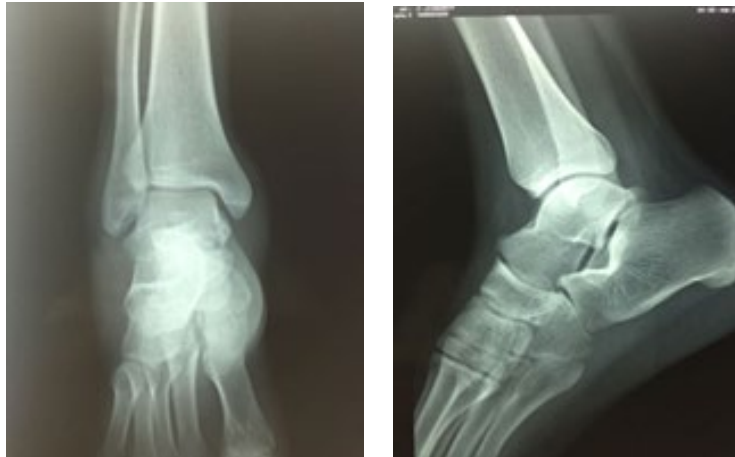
Post-reduction radiograph: alignment of anatomical landmarks without associated lesions
